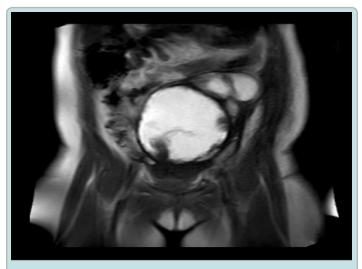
CT image of abdomen and pelvis showing central mass.
